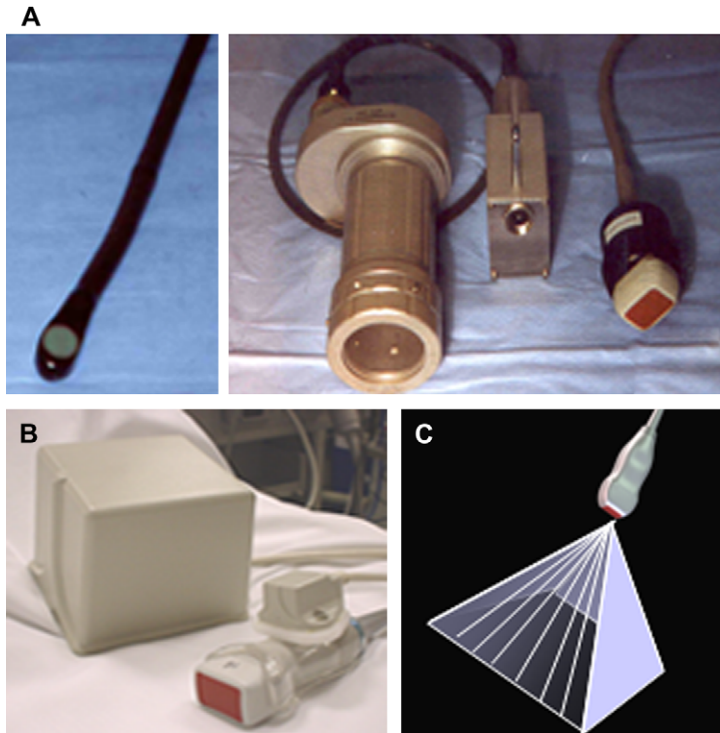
Acquisition methods. (A) Rotational gated sequential acquisition method using a transesophageal probe or transthoracic transducer coupled in a mechanical rotational device. (B) Free-hand method using magnetic sensor and transmitter. (C) Fully-sampled matrix array transducer acquires a pyramidal volume data set consisting of seven subvolumes for color acquisition.
